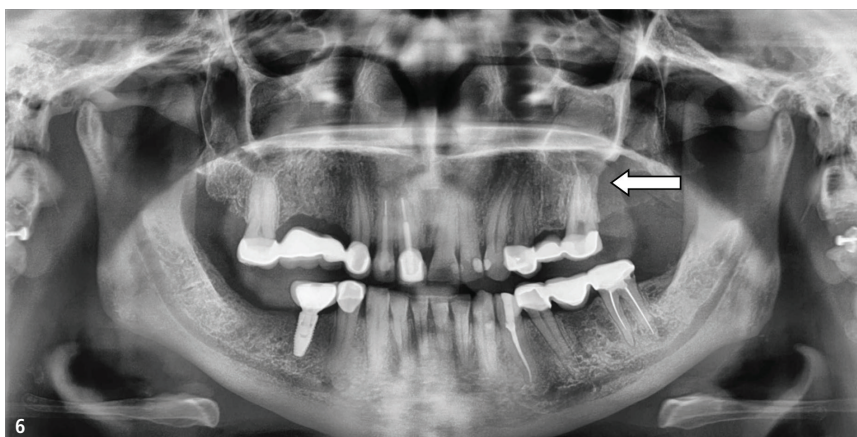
Orthopantomograph showing loss of posterior antral wall on the left side in a patient with a large odontogenic keratocyst. – Fig. 7: Periapical showing loss of posterior antral wall in maxillary odontogenic keratocyst.
